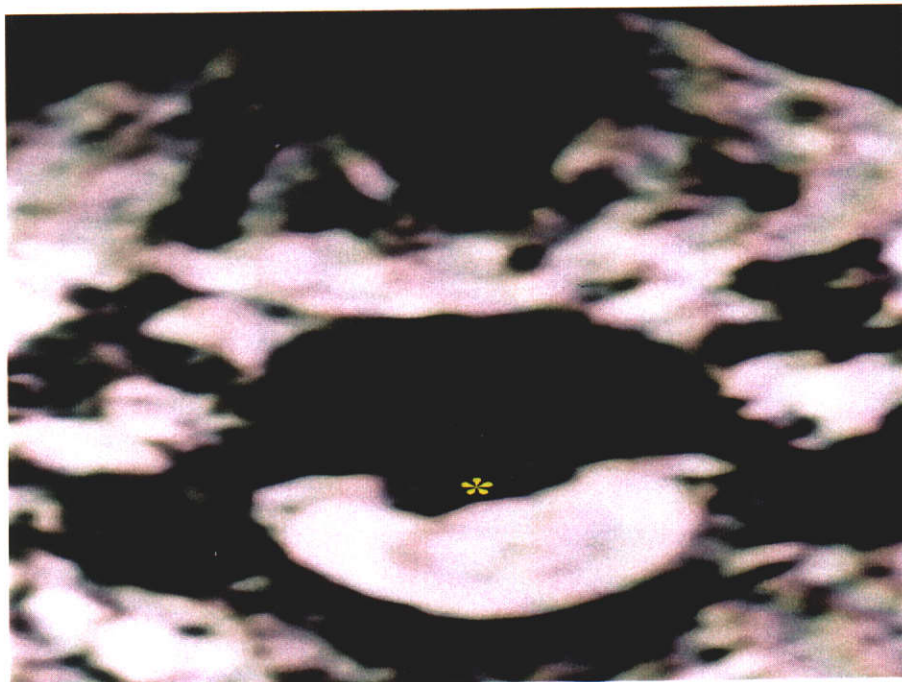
MRI of a "whiplash" patient demonstrating disc lesion causing indentation of the subarachnoid space.
